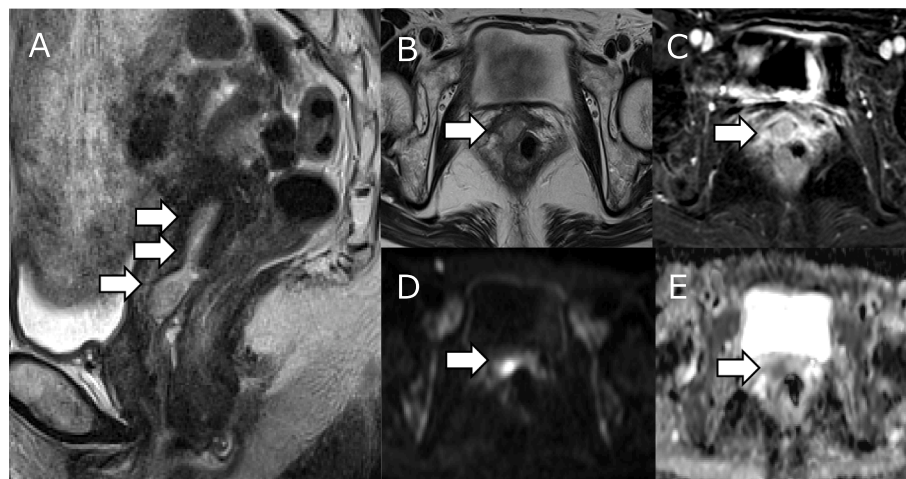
Magnetic resonance imaging of the polypoid mass. A: sagittal and B: axial T2-weighted image showing an intermediate signal polypoid mass protruding from the anterior wall of the uterus to the vagina. C: Contrast-enhanced axial fat-saturated T1-weighted image shows the mass with moderate enhancement. D: Diffusion-weighted image ($b = 800$) and E: Apparent diffusion coefficient map shows diffusion restriction of the mass.
